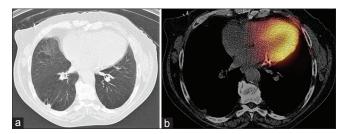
Selected axial low-dose computed tomography (a) image acquired for attenuation correction during myocardial perfusion scintigraphy (acquired in prone position). An incidental 10 mm opacity is seen within the right lower lobe. Further evaluation with full-dose diagnostic-quality computed tomography was recommended. Anatomical equivalent (b) shown on single-photon emission computed tomography
